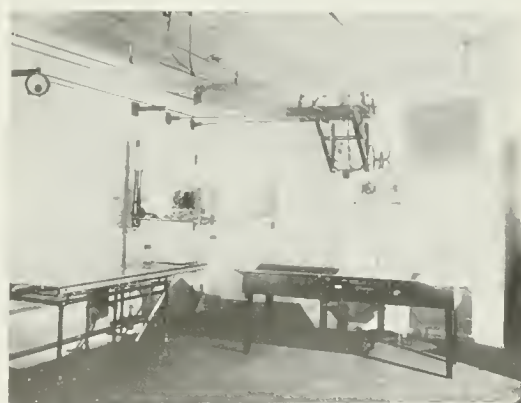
A portion of the general roentgenographic room.
